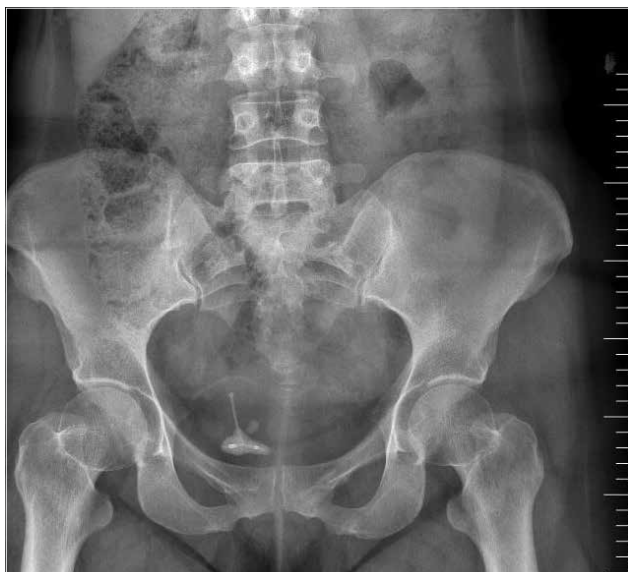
Encrusted intrauterine contraceptive device in the pelvic area. Plain abdominal radiography image.
